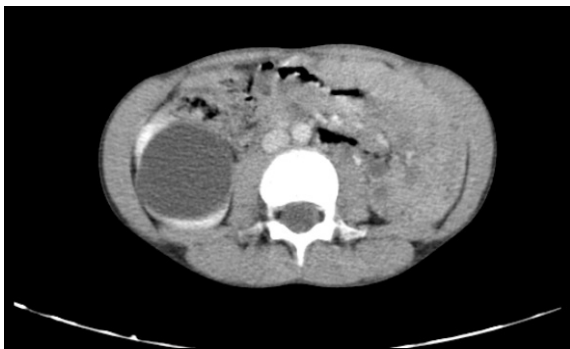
CT scan showing right renal cyst without septa and calcification.
